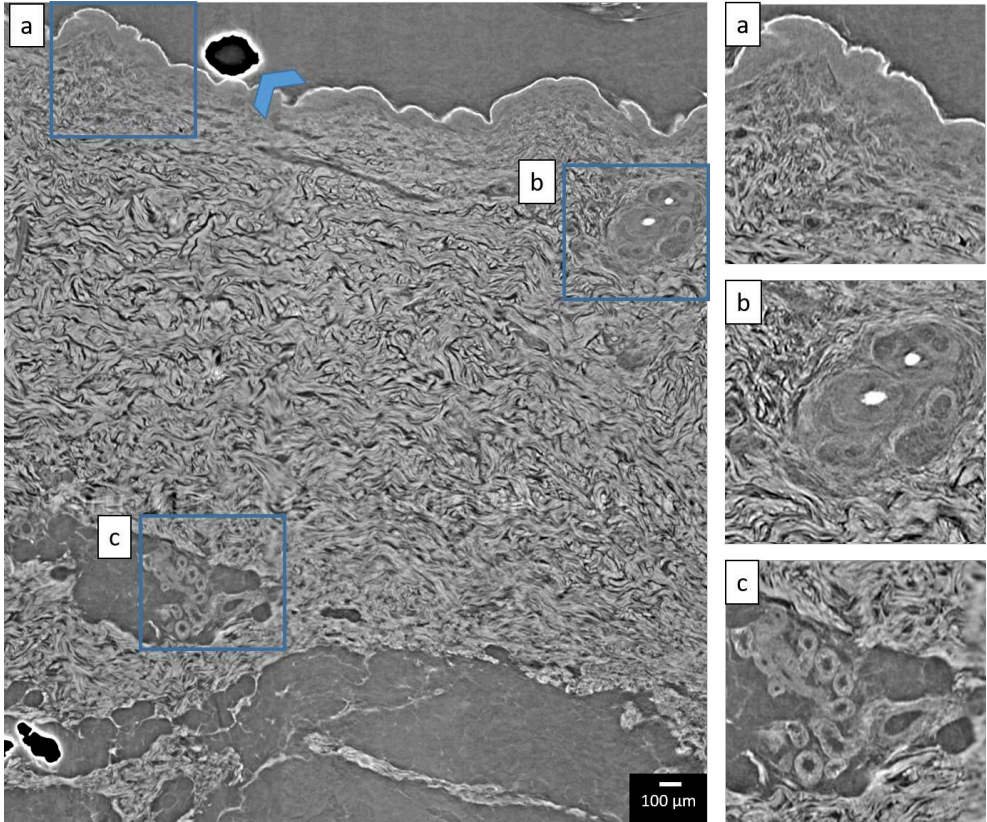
Skin tissue embedded in paraffin block and considered for XPCT investigation at the SYRMEP beamline of the Elettra synchrotron (Trieste, Italy). On the right, some zoomed details representing (a) epidermal-dermal layer junction, (b) hair follicle within dermis, (c) hypodermal layer with a blood vessel circumscribed by sweat glands. The experiment was conducted in parallel geometry, using the propagation-based setup available (polychromatic beam, average X-ray energy: 21 keV, pixel size: 2.0 μm , SDD: 20 cm).
